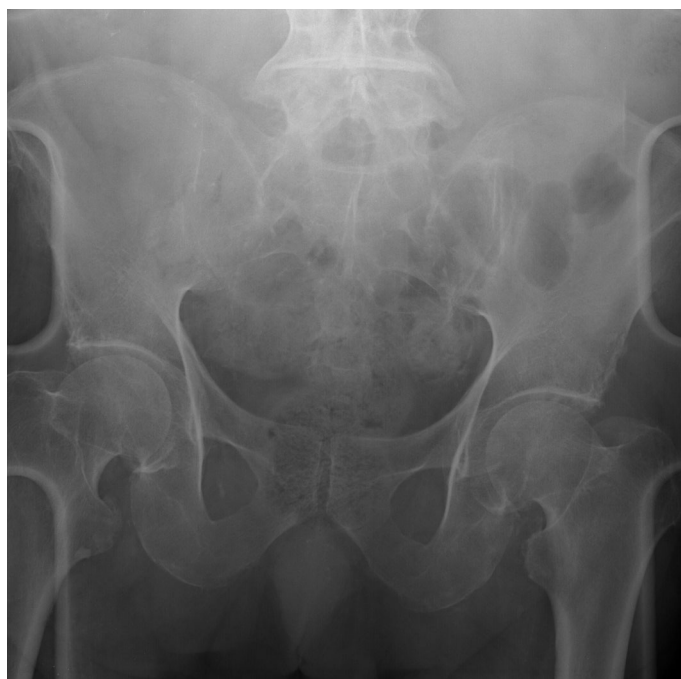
Anteroposterior x-ray of the pelvis shows no evidence of fusion, erosion, or sclerosis of the sacroiliac joint.
